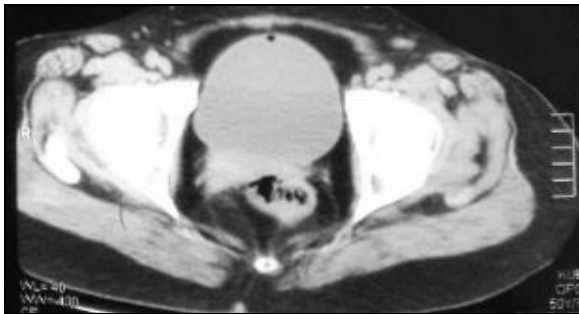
Emphysematous cystitis (speck air seen anterior wall of urinary bladder on computed tomography axial view)
